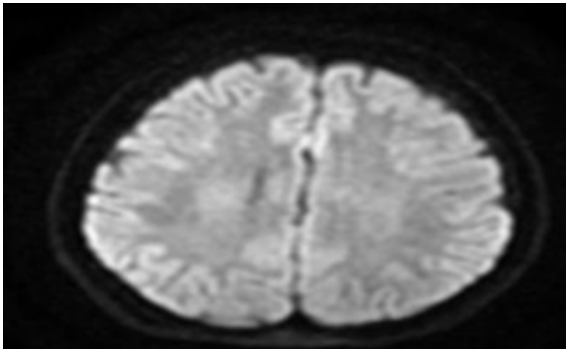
Diffusion-weighted MRI demonstrating no abnormal restriction of diffusion, consistent with the absence of acute parenchymal lesions.
